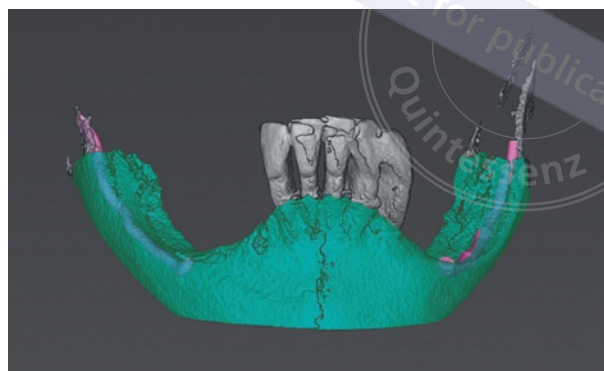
Initial situation: CBCT analysis of the mandible. The CBCT showed a significant difference in bone height between the highly atrophic posterior region and the mandibular residual dentition.
